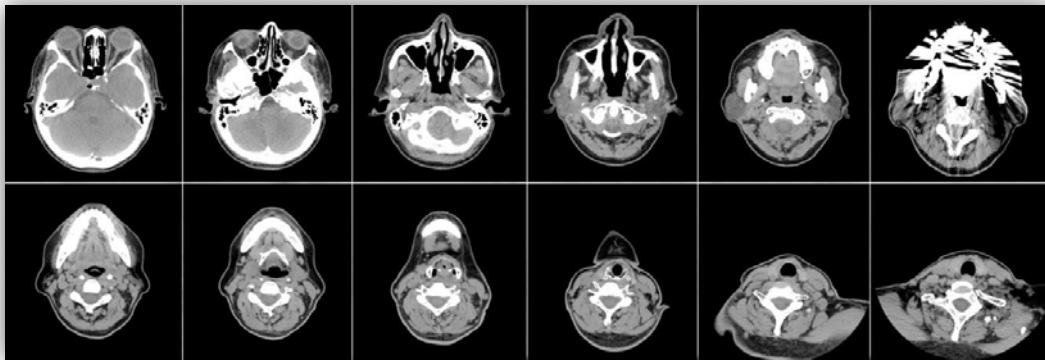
A set of CT slices in axial plane of a human upper airways
